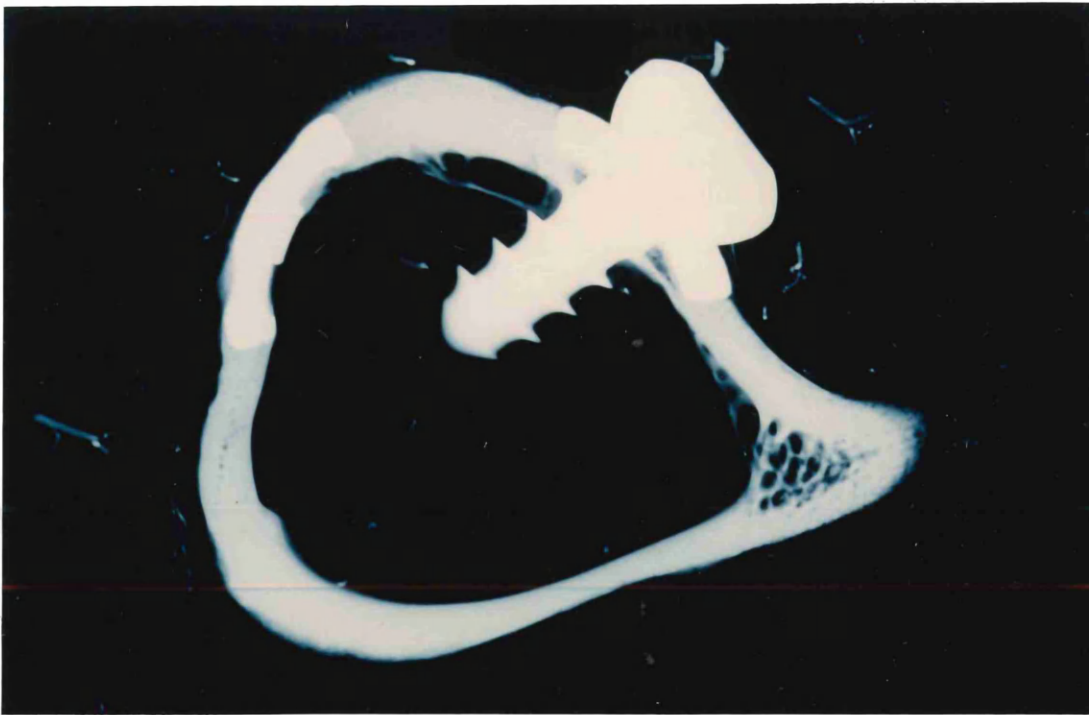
A radiograph of a transverse section through the proximal region of the 2 plated implant shown in fig. 10.
